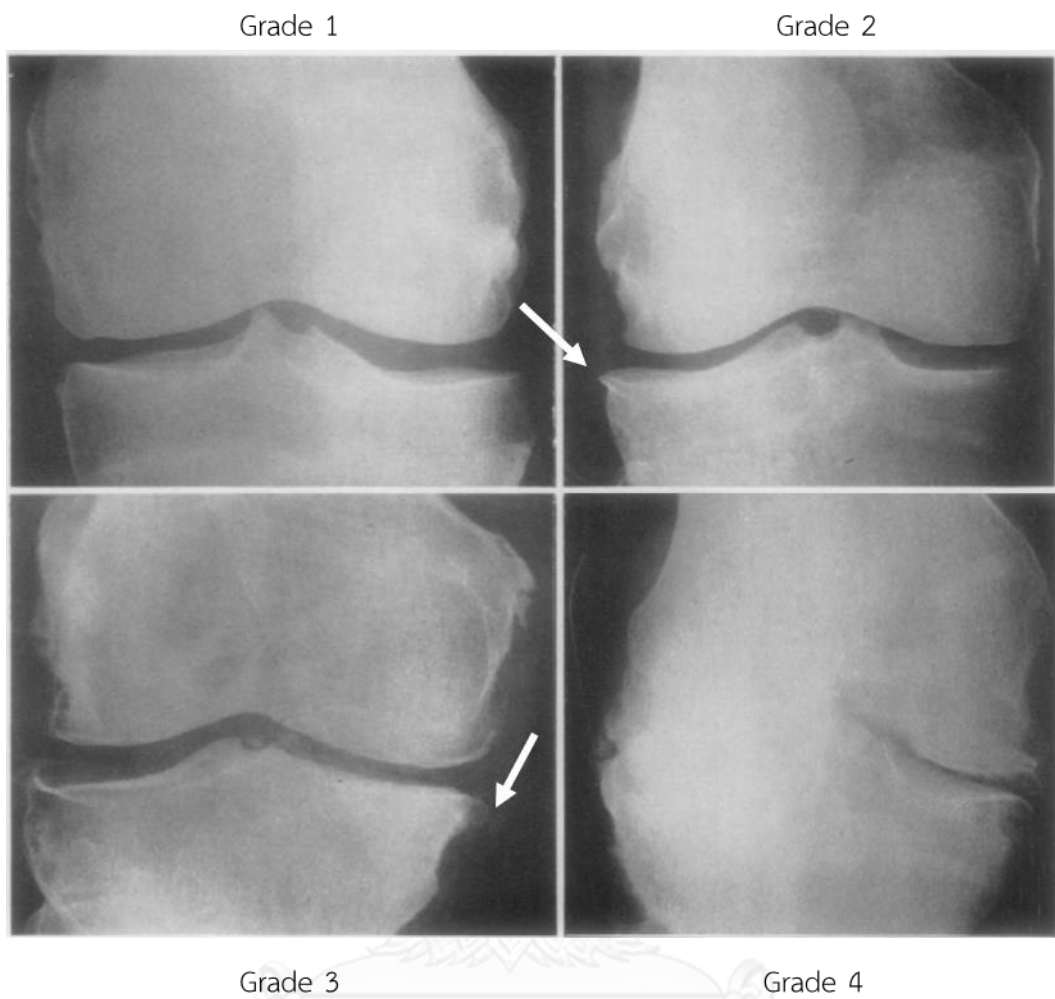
Classification of the severity of knee osteoarthritis using X-ray film, arrows indicate osteophyte formation (Kellgren and Lawrence 1957)
